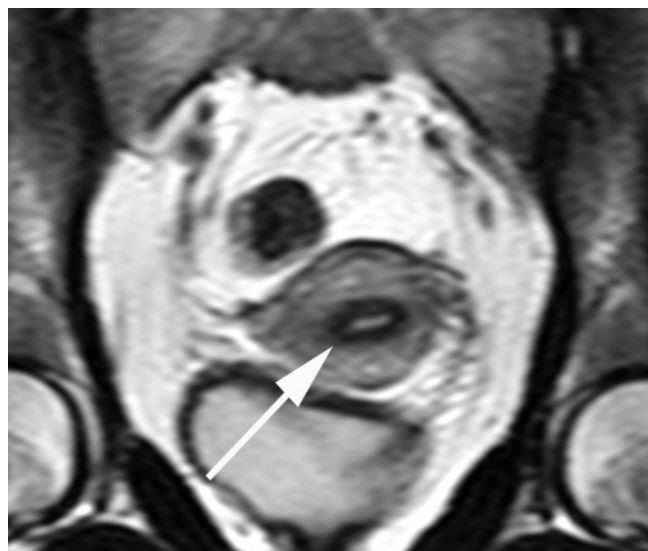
Short-axis view of the uterus. T2-weighted ETSE sequence perpendicular to the endometrial canal shows the uterine zonal anatomy: central hyperintense endometrium, low-signal-intensity junctional zone (arrow) representing the innermost myometrium, and outer intermediate-signal-intensity myometrium.
